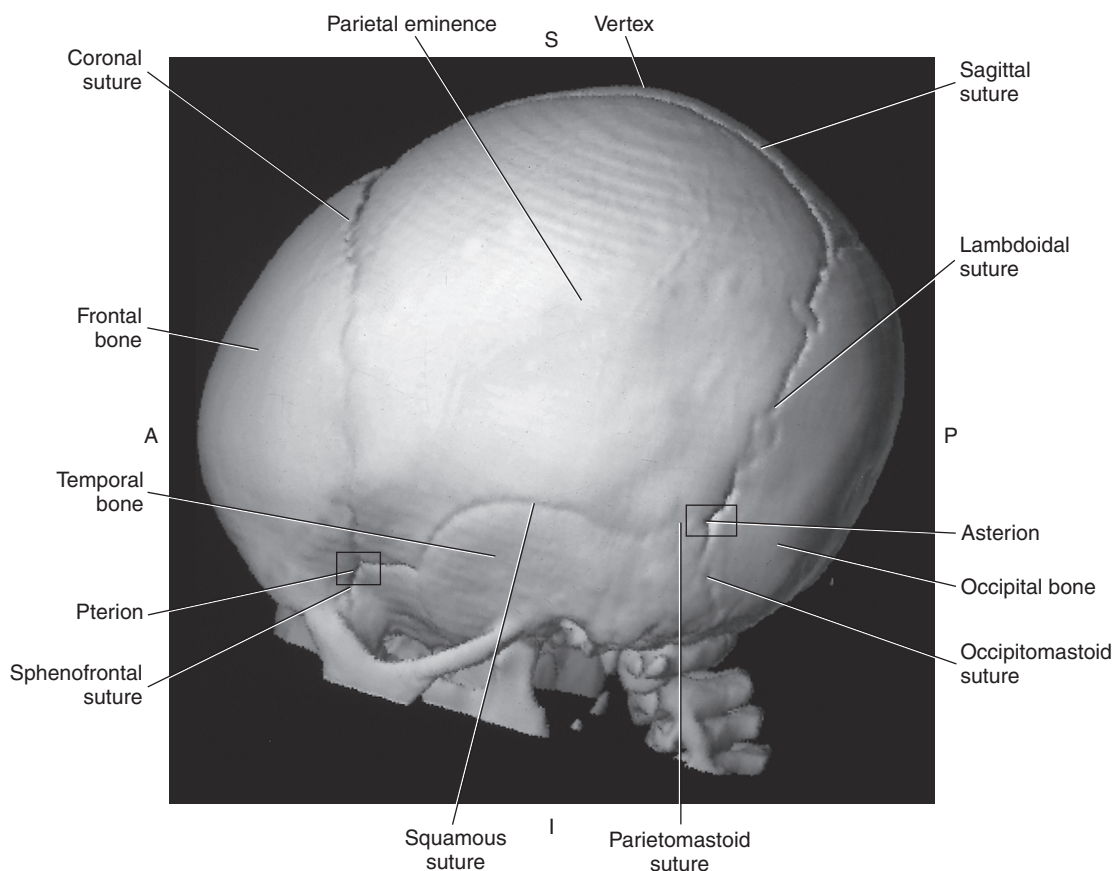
3D CT of lateral surface of cranium.
